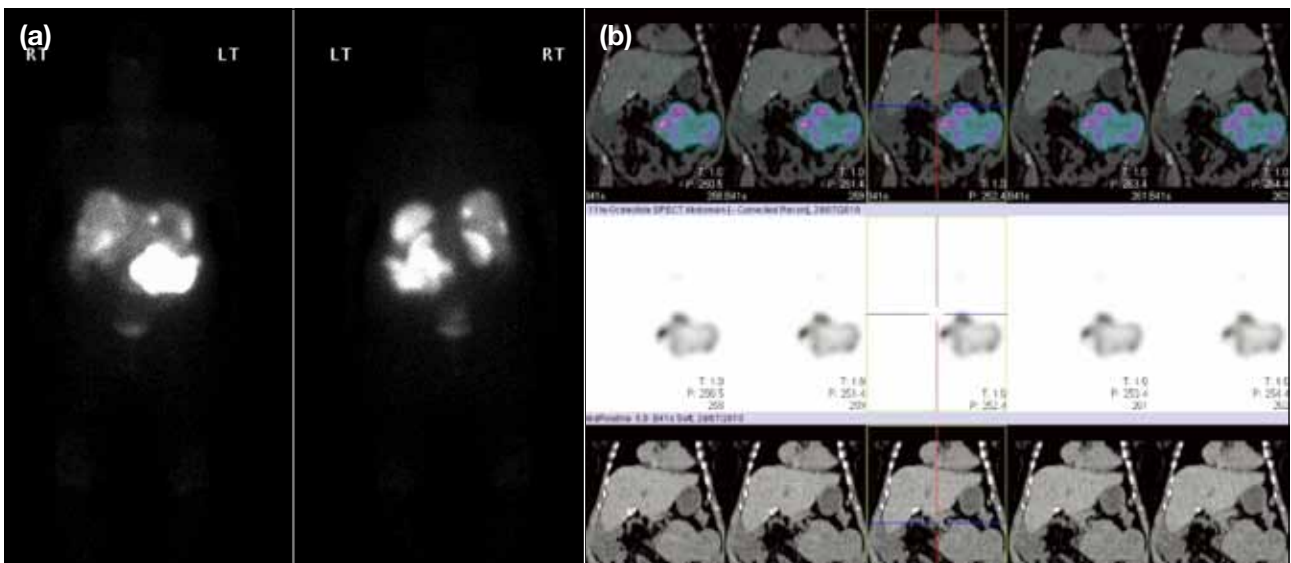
(a) A patient with known metastatic midgut neuroendocrine tumour showing multiple foci of increased tracer uptake within the liver and mid abdomen on the whole-body ^{111}In -pentetreotide images. (b) The single-photon emission computed tomography–computed tomography (SPECT-CT) images show a large mesenteric mass just anterior to the aorta (note: fused images in top row, ^{111}In -pentetreotide images in middle row and CT bottom row).
